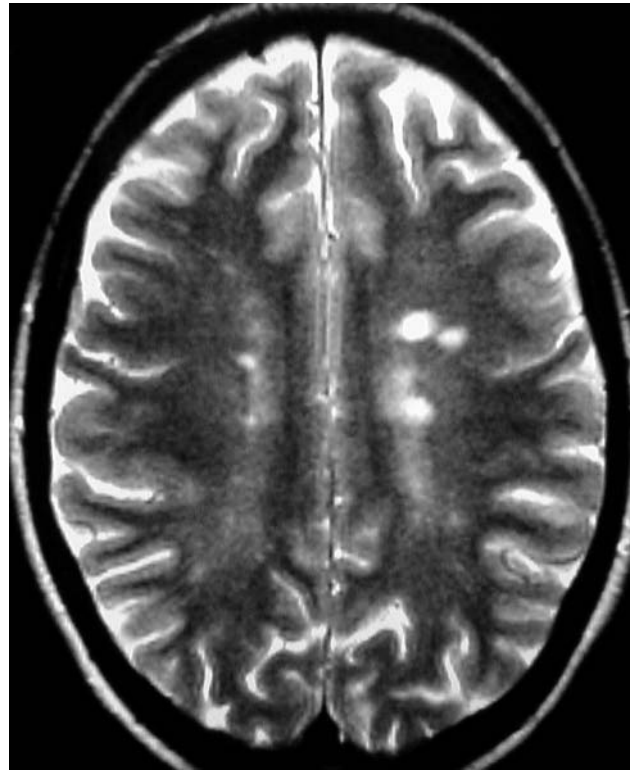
MRI image of a patient with optic neuritis in the setting of known multiple sclerosis (MS): The typical, white foci of increased signal intensity in T2-weighted images mark the presence of large plaques of demyelination
